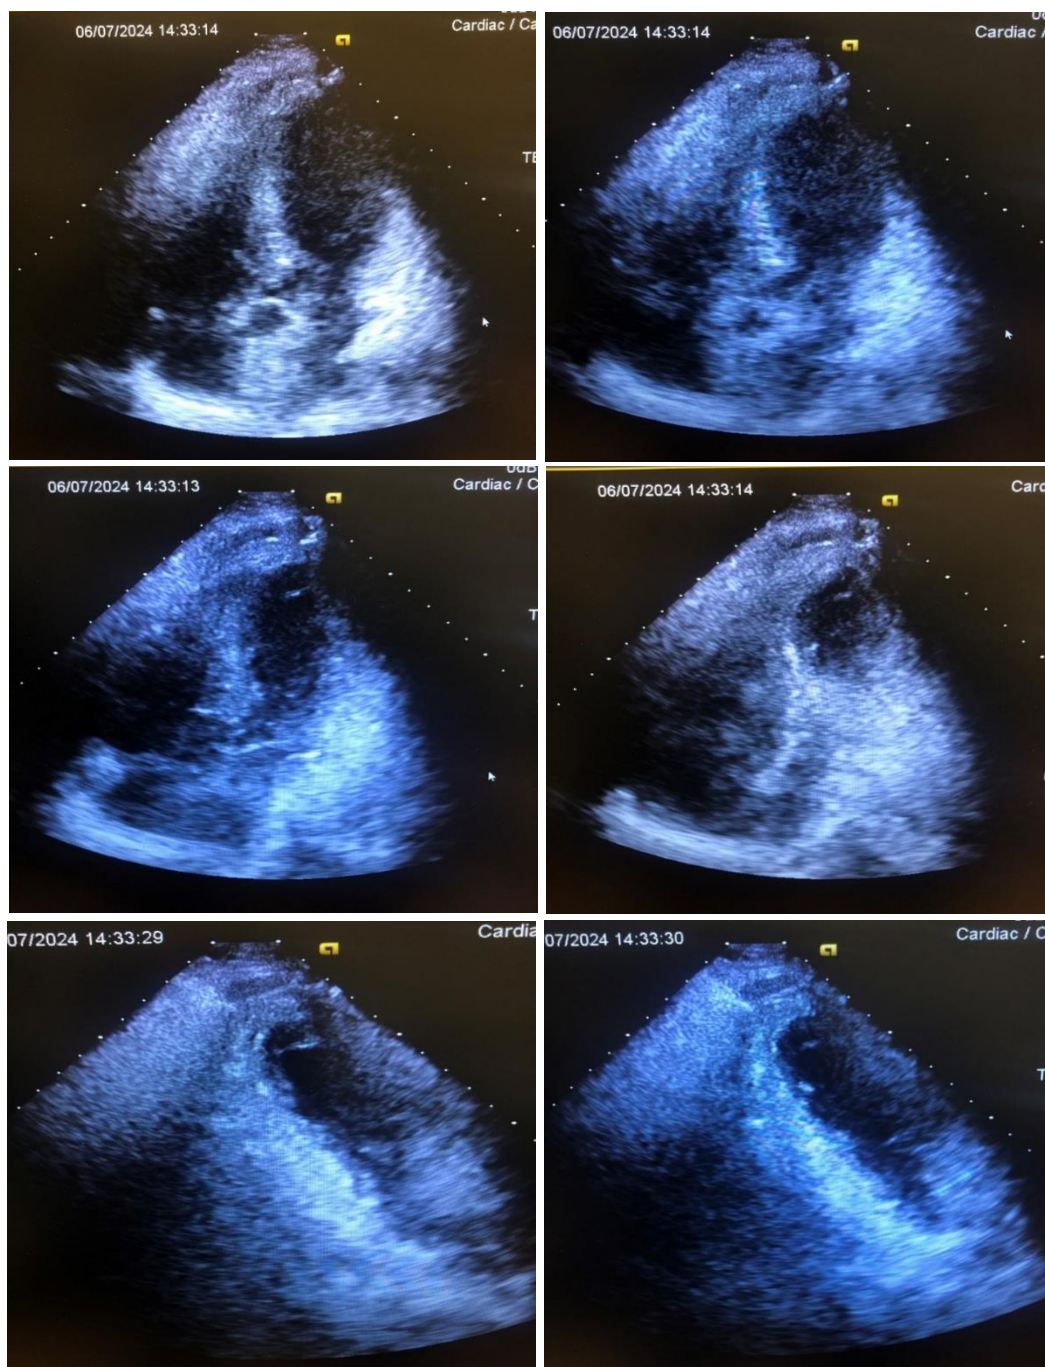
Echocardiography of patient showing Takotsubo cardiomyopathy. Echocardiography at the catheterisation laboratory showing an apical balloon like cardiomyopathy, setting the diagnosis of Takotsubo cardiomyopathy.
